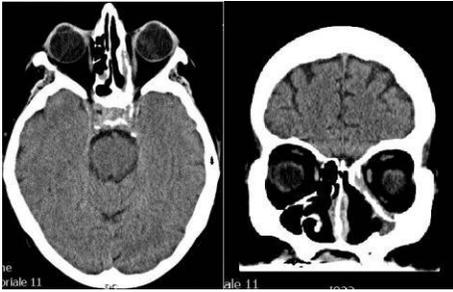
CT: no evidence of gross pathology
